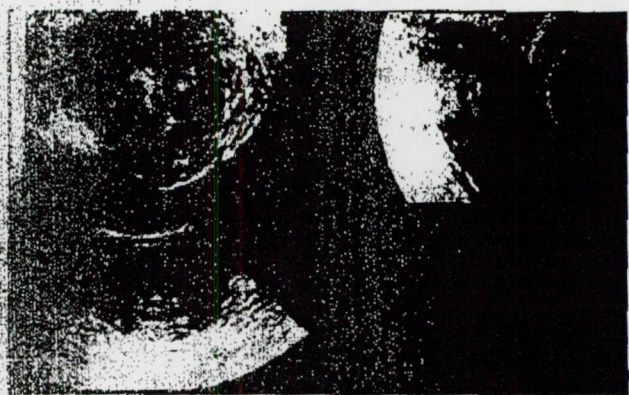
The endometrium can be observed in three perpendicular planes using 3D ultrasound. The echo-free area in the endometrium corresponds to the area that was not filled with contrast fluid during the HSG examination.
